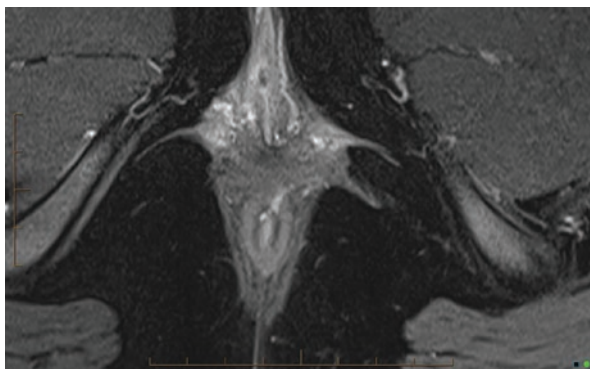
Axial MR image of anterior transphincteric fistula crossing the EAS at 1 o'clock with predicted internal opening at this level
